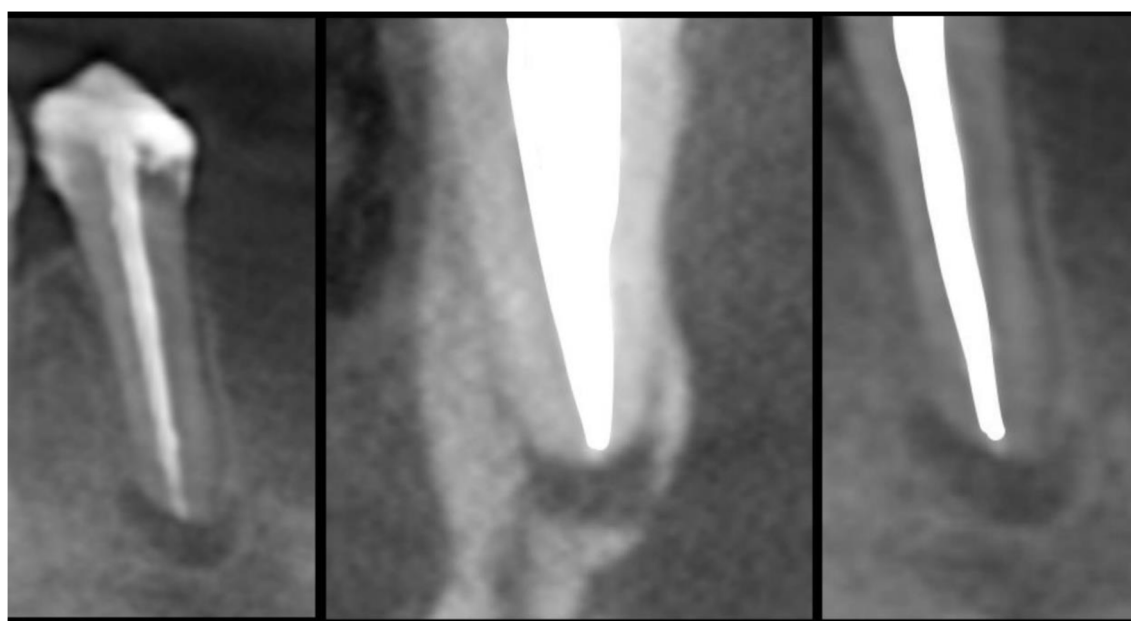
An example of a tooth without an intra-radicular post with a periapical radiolucent lesion (coronal and sagittal)
